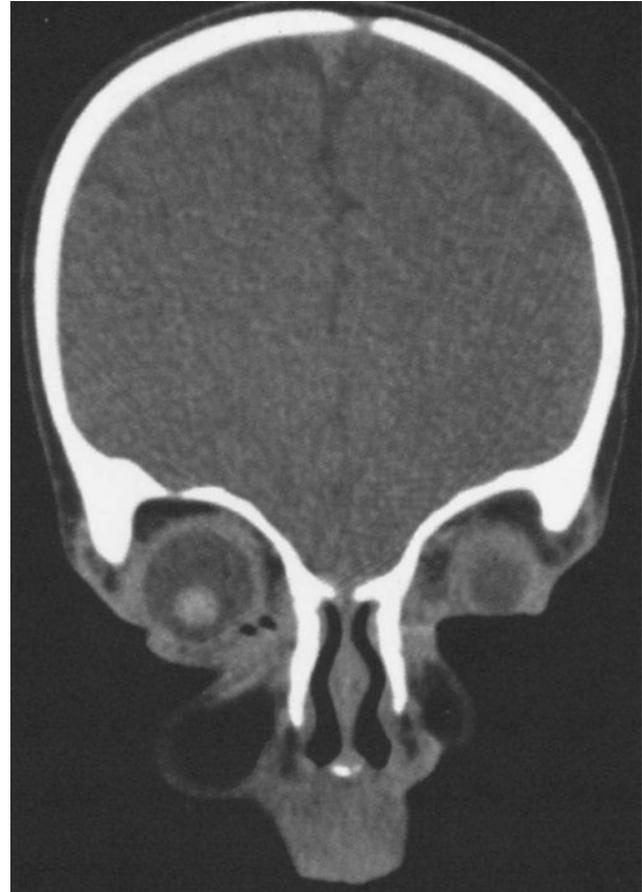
A computed tomographic scan, coronal view, showing the bony canal of a dermal sinus tract anterior to the crista galli and cribriform plate.
